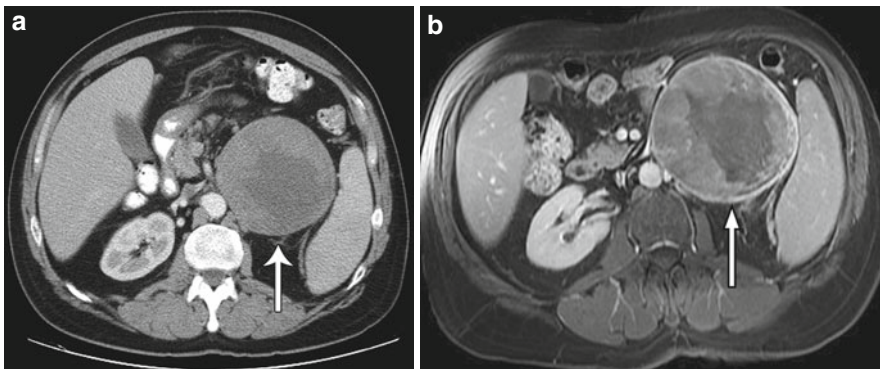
Adrenal cortical carcinoma. (a) Contrast-enhanced CT shows a 11 × 16 cm left adrenal mass (*arrow*), with a large central region of low attenuation indicating necrosis and/or hemorrhage. (b) Gadolinium-enhanced MR shows a similar mass (*arrow*) with central low signal intensity
